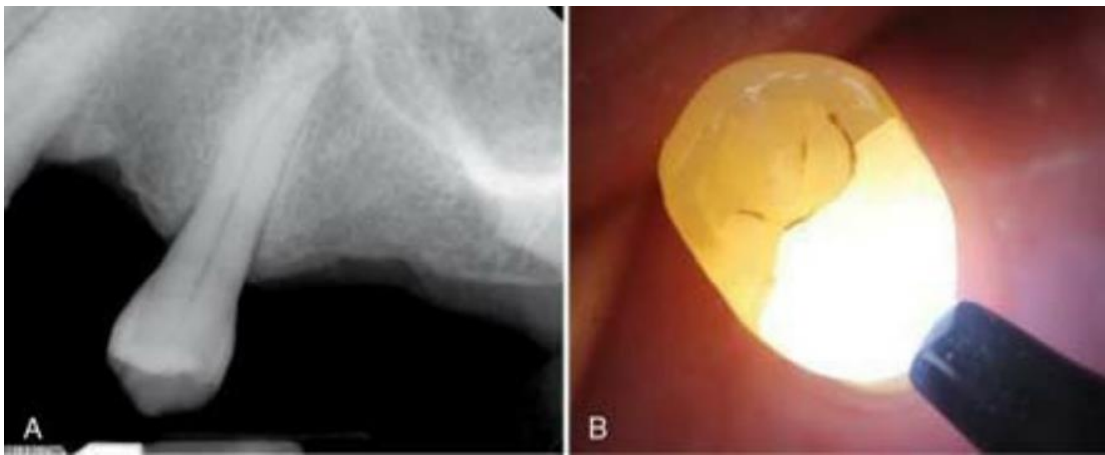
Cracked teeth detection. A, Preoperative radiograph. B, Transillumination (Pathways of the pulp 12th edition)
